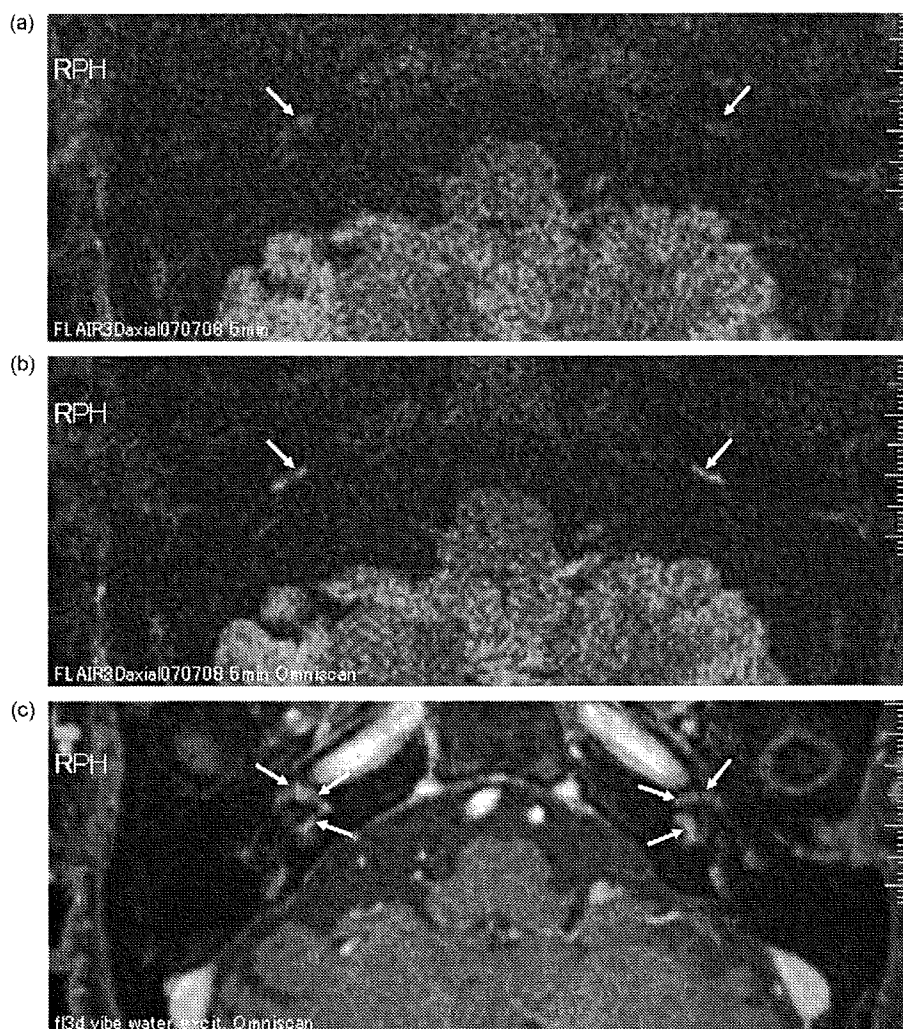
Axial magnetic resonance imaging (MRI). (a) Three-dimensional fluid-attenuated inversion recovery (3D-FLAIR) images before enhancement. Bright signals are faintly visible bilaterally in the cochleas (arrows). (b) 3D-FLAIR after enhancement. Gadolinium enhancement is seen bilaterally in the cochleas (arrows), especially in the basal turn of the left cochlea. (c) Enhanced T1-weighted MRI. Bilateral enhancement of the soft tissue around the cochleas is seen (arrows). However, the high-signal areas visualized on 3D-FLAIR after enhancement were not detected.
